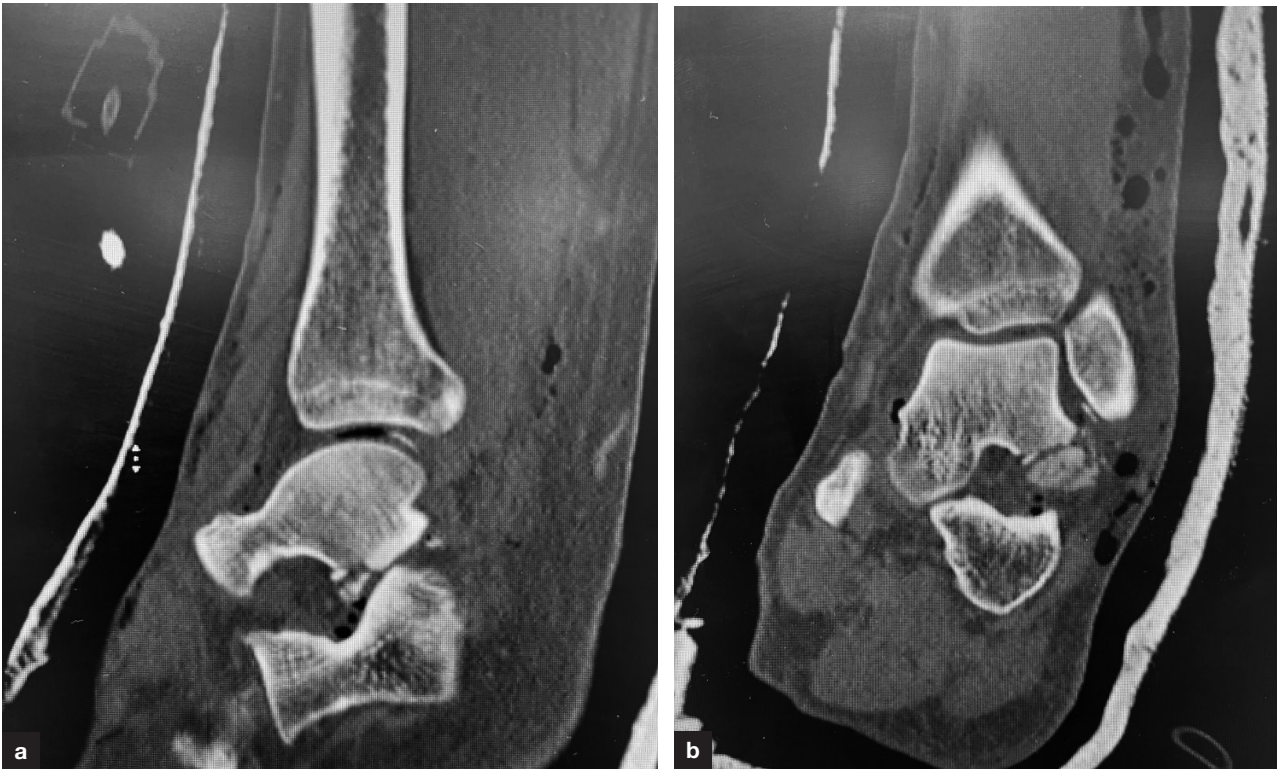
a. Sagittal reformatted computed tomography scans of the ankle and hindfoot showing a lateral process fracture of the talus. These injuries can easily be missed on plain X-rays. Also note the subcutaneous emphysema posteriorly. This patient presented with an open lateral subtalar dislocation (same patient in [Figure 6](#)). b. Coronal reformatted computed tomography scan demonstrating the lateral process talus fracture and subcutaneous emphysema.
